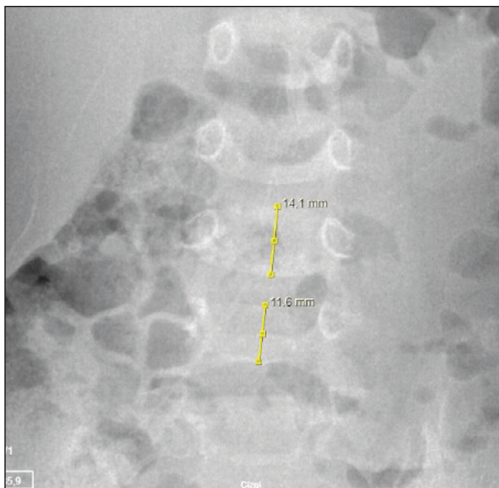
Radiograph indicating a loss of height in 5th lumbar vertebra compared to that of 4th lumbar vertebra in a 4-year and 3-month-old child.
